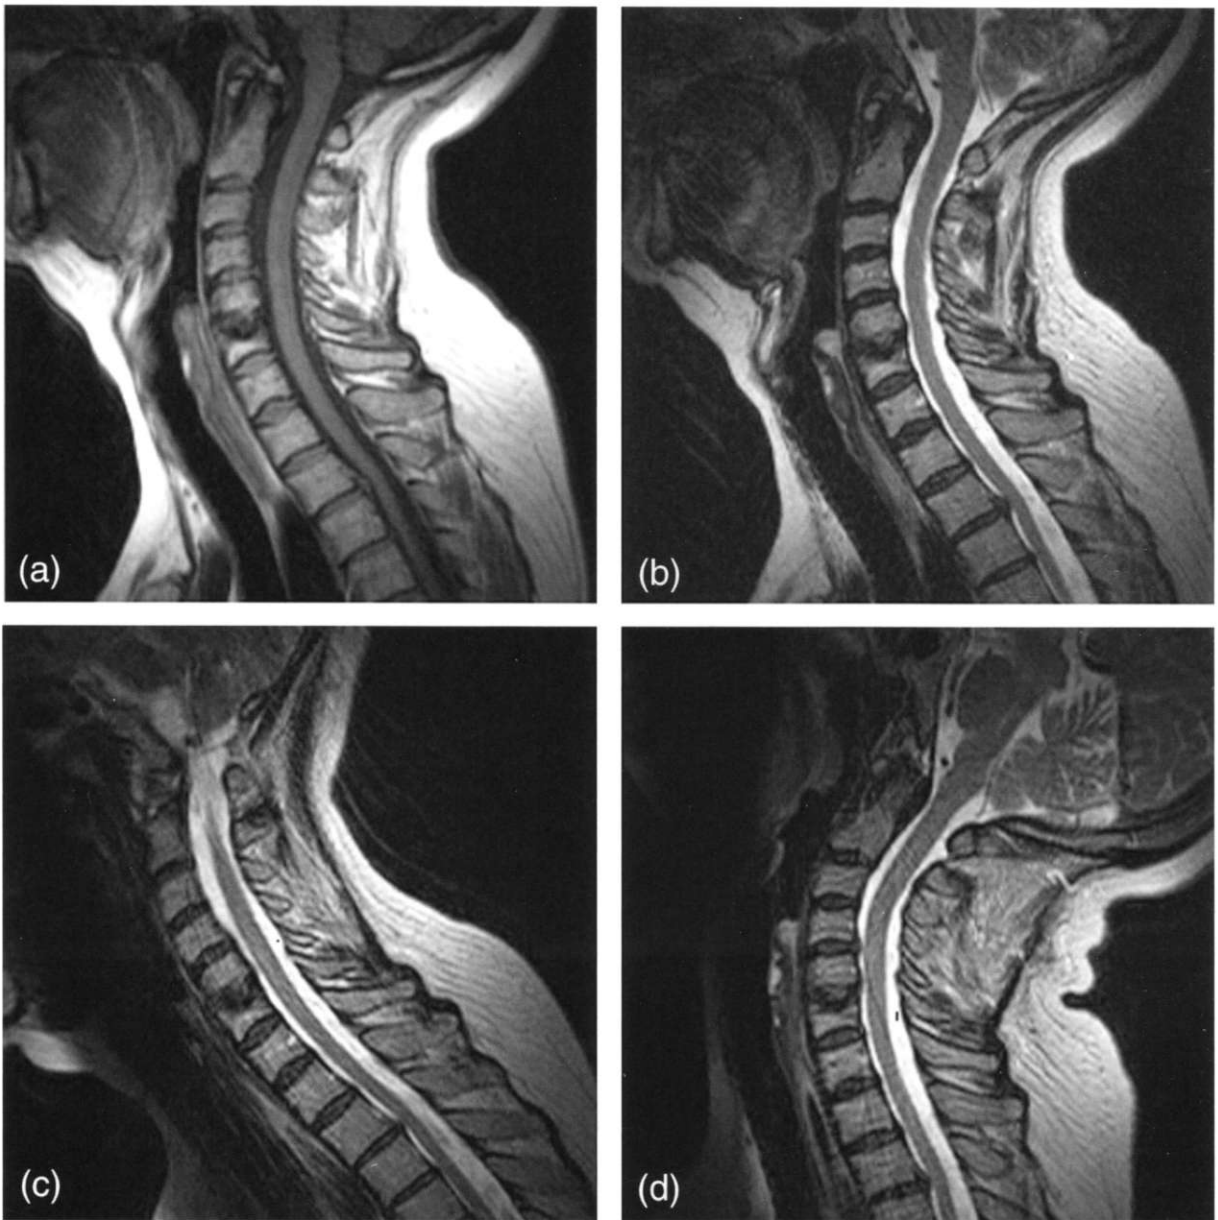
Postoperative intersegmental fusion stability (4 years status-post clinically successful interbody bone graft fusion). (a) Upright-neutral midline sagittal T1-weighted fast-spin echo MRI (pMRI) shows the surgical fusion at C5–C6; autologous bony dowels were used for the original fusion performed 4 years prior to the current examination. Note the normal bony intersegmental alignment and postural sagittal lordotic curvature. Also note the posterior focal disc herniation at the T2–T3 level. (b) Upright-neutral midline sagittal T2-weighted fast-spin echo MRI (pMRI) again shows the intersegmental fusion. Note the good CSF spatial dimensions surrounding the spinal cord. The prominent disc herniation is again noted at the T2–T3 level. (c) Upright-flexion midline sagittal T2-weighted fast-spin echo MRI (kMRI) shows no intersegmental slippage at, suprajacent to, or subjacent to the surgically fused level. Note the maintenance of the anteroposterior dimension of the central spinal canal. Also note that the T2–T3 disc herniation is somewhat smaller on this flexion study as compared to b or d. (d) Upright-extension midline sagittal T2-weighted fast-spin echo MRI (kMRI) again reveals no intersegmental hypermobile instability or central spinal canal compromise at any level.
